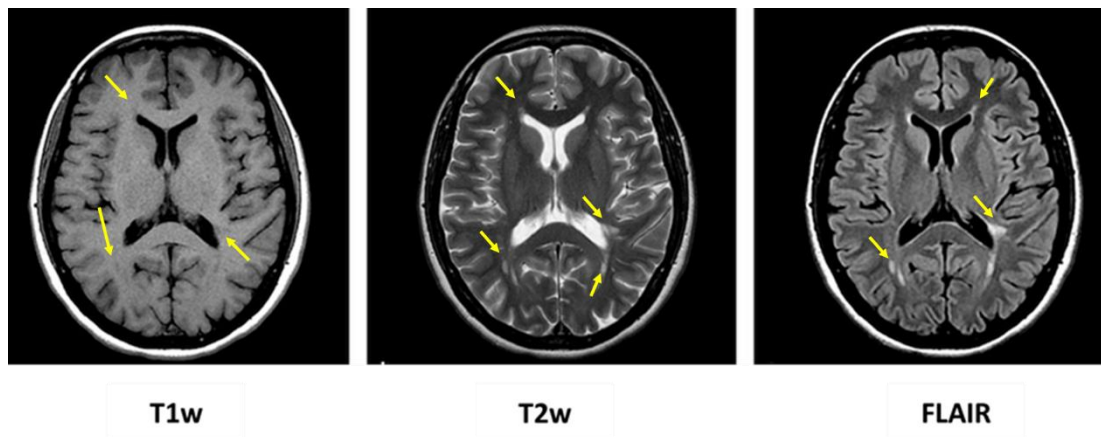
MRI sequences commonly used in MS. These are the typical sequences used in routine clinical practice. The images have been obtained from an RRMS patient who is taking dimethyl fumarate.
